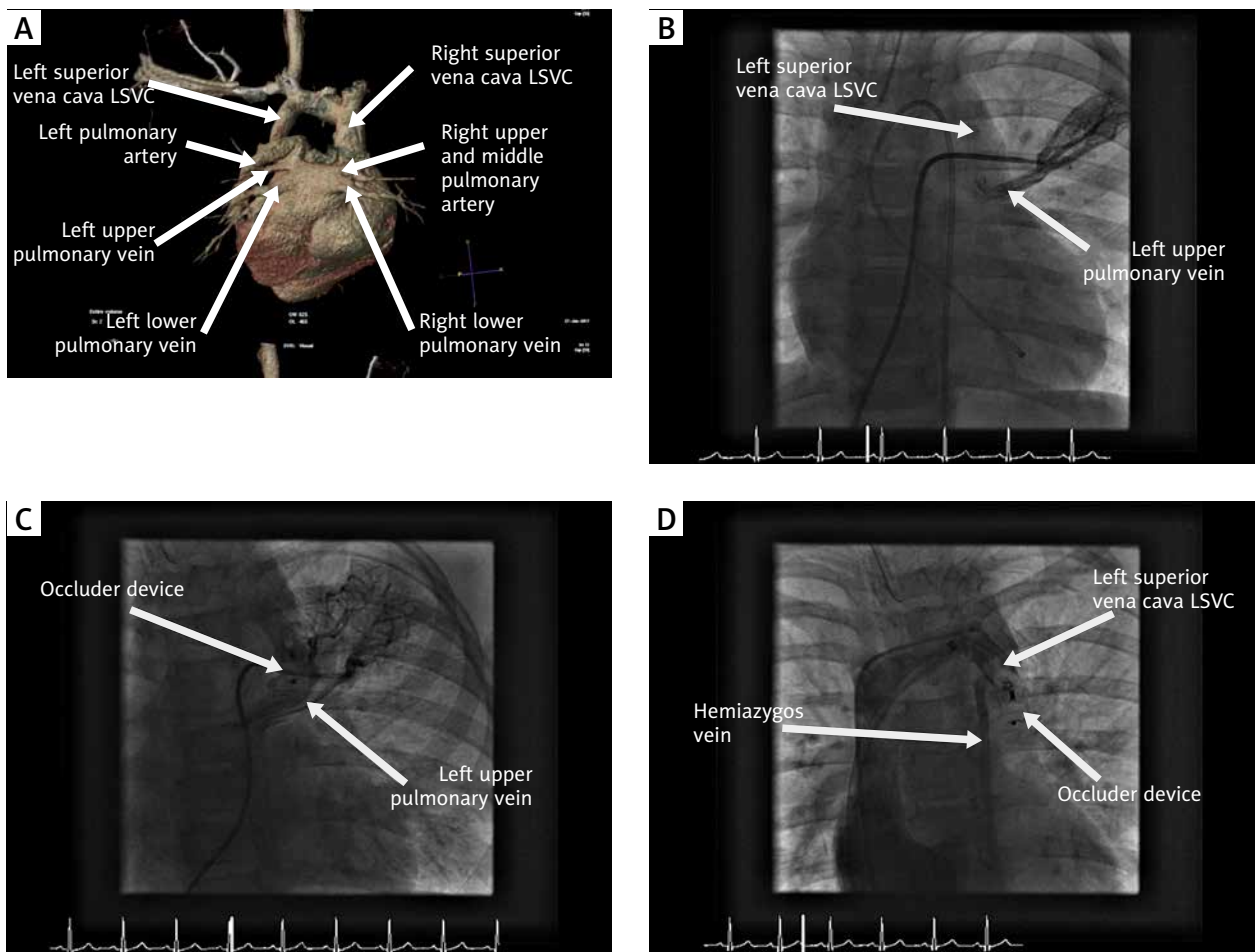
A – Computed tomography reconstruction: the left superior vena cava draining to the left atrium with a suspicion of the left upper pulmonary vein draining to the left superior vena cava, B – angiography: the left upper pulmonary vein draining to the left superior vena cava with the flow towards both the bridging vein and the left atrium, C, D – Angiography after implantation of an Amplatzer Duct Occluder device (12/10 mm) in the left superior vena cava, below the hemiazygos vein and just above the orifice of the left upper pulmonary vein, with the left upper pulmonary vein flow redirected to the left atrium
